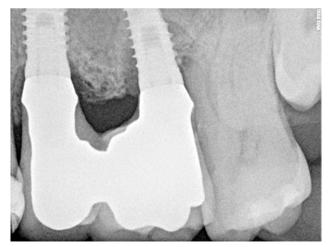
Case 1: Initial periapical x-ray.
